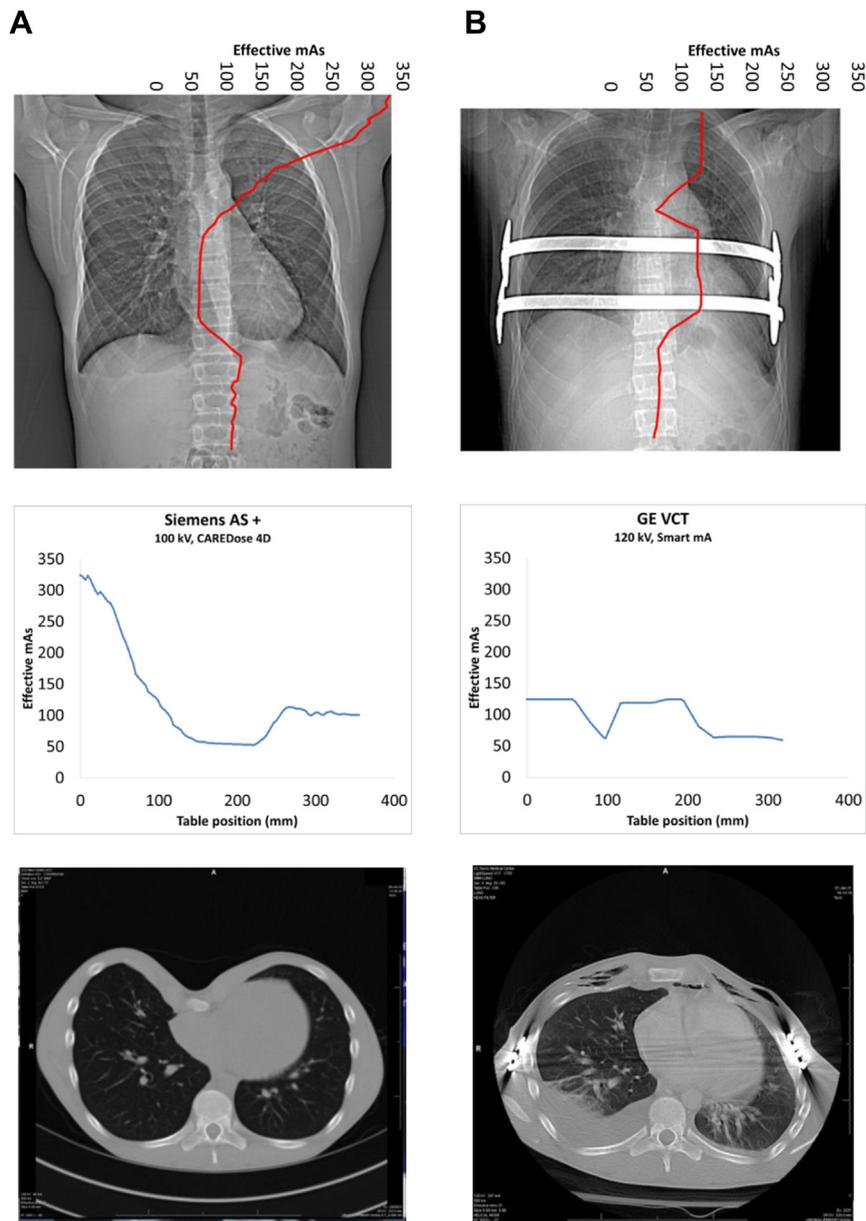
(A) Presurgery scan, Siemens Definition AS+, 100kV, CareDose4D. Top: CT localizer radiograph with mA modulation and effective mAs scale superimposed. Middle: tube current modulation with table position “0” at top of localizer. Bottom: Reconstructed axial scan. (B) Postsurgery scan, GE VCT, 120 kV, Smart mA. Top: CT localizer radiograph with mA modulation and effective mAs scale superimposed. Middle: tube current modulation with table position “0” at top of localizer. Effective mAs is calculated by dividing mAs/slice by pitch. Bottom: Reconstructed axial scan. kV = kilovolt; mA = milliamperere.
